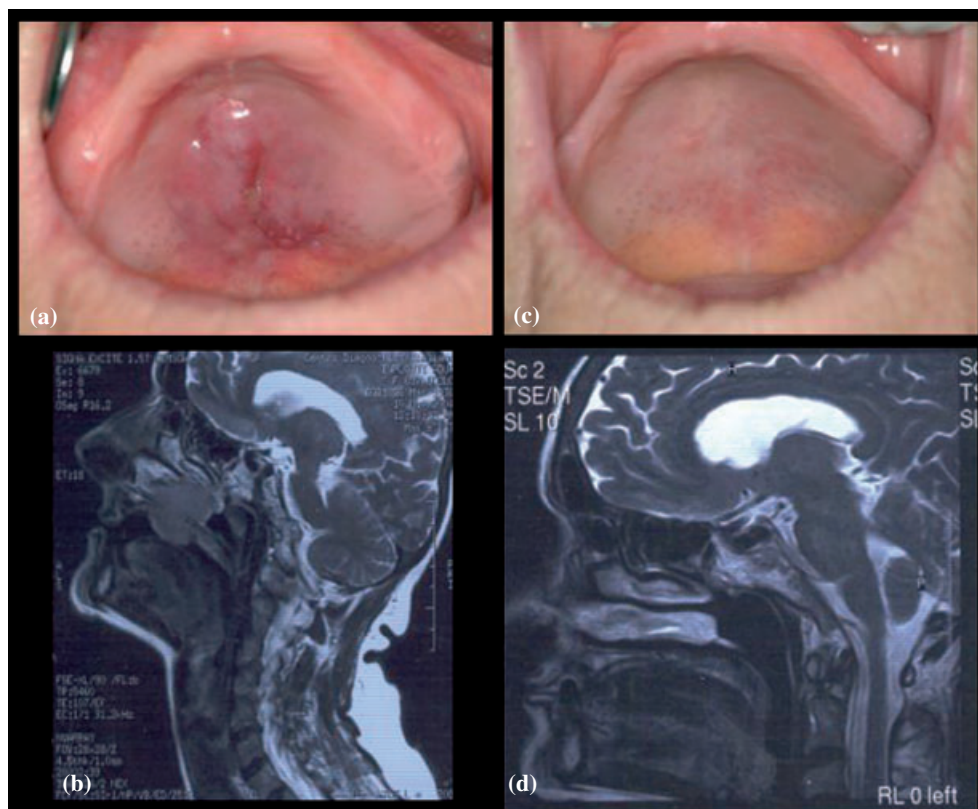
(a) Intraoral appearance of patient at the time of initial presentation. (b) Magnetic resonance image showing the paranasal sinus filled with tumor mass destroying the palatal bone. (c, d) Clinical and radiographic remission of the tumor by chemotherapy.
